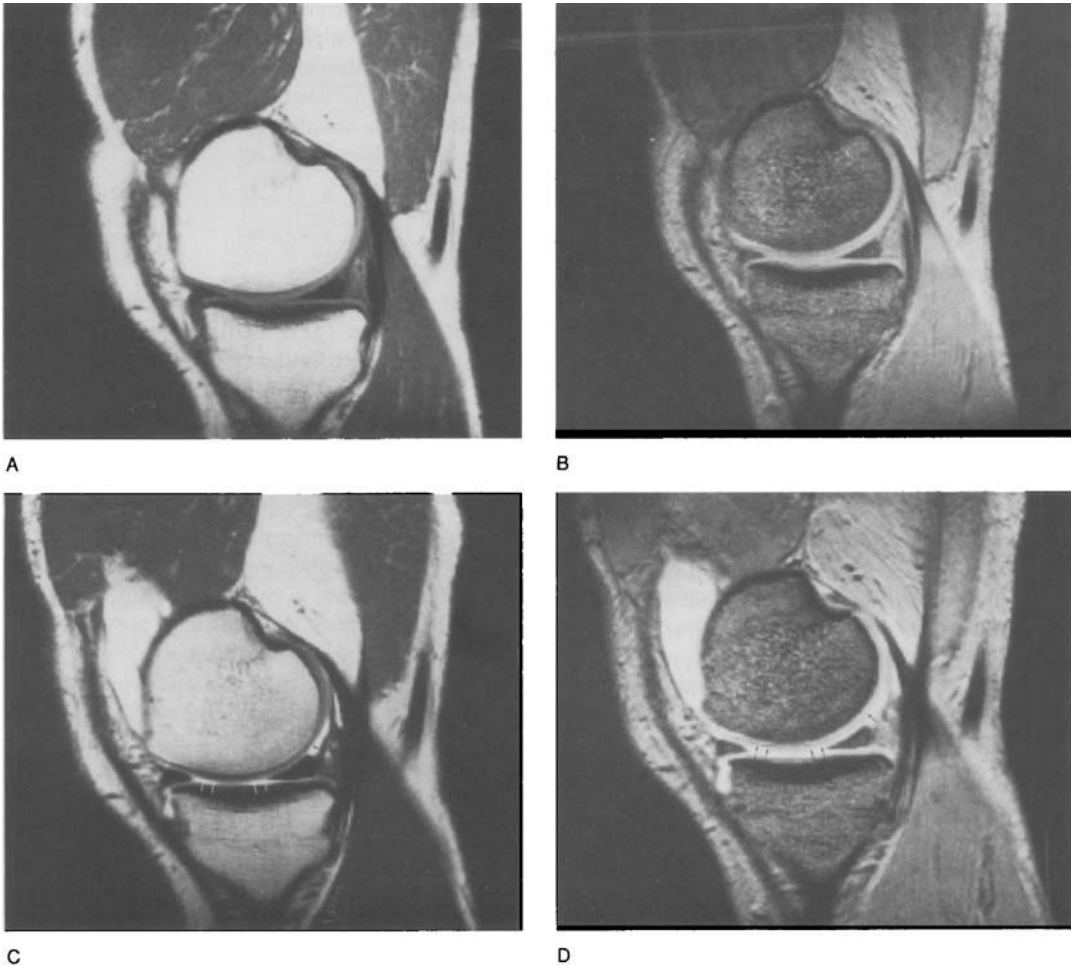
MRI, SE 700/15 (A+C), GE 30/10/30°, FISP-3D (B+D), normal knee-joint, sagittal plane, medial femoral condyle.
